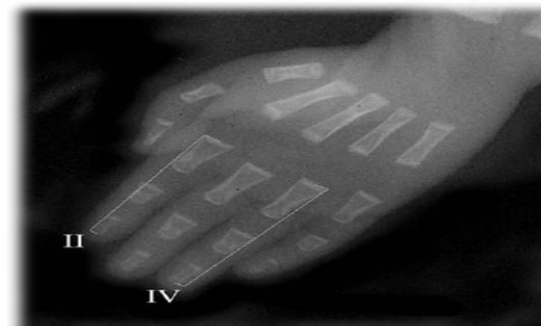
Radiograph of right hand.
